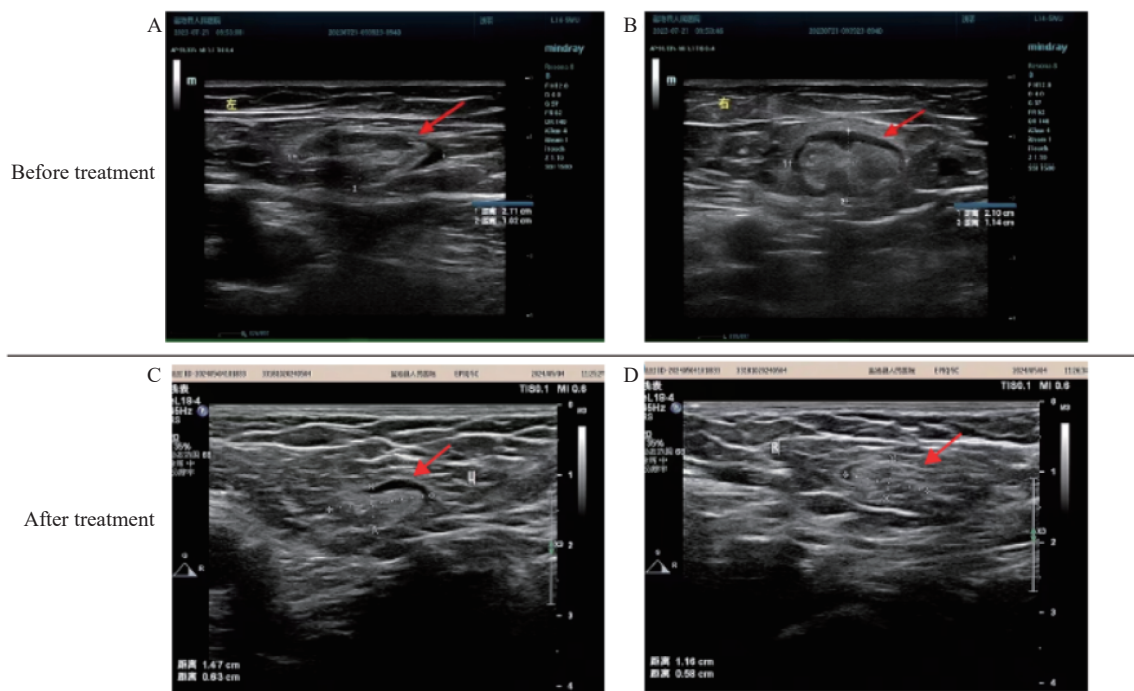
Computed tomography results of the case. (A) Left and (B) right inguinal lymph nodes before treatment; (C) Left and (D) right inguinal lymph nodes after treatment.
